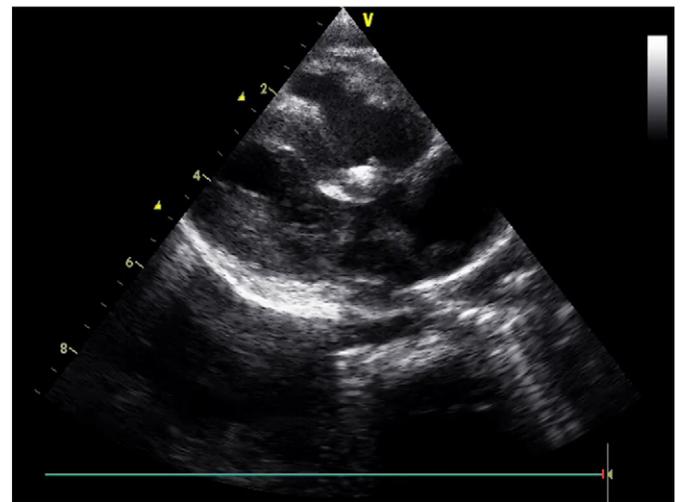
Echocardiographic image of VSD after closure with ADO II device.
